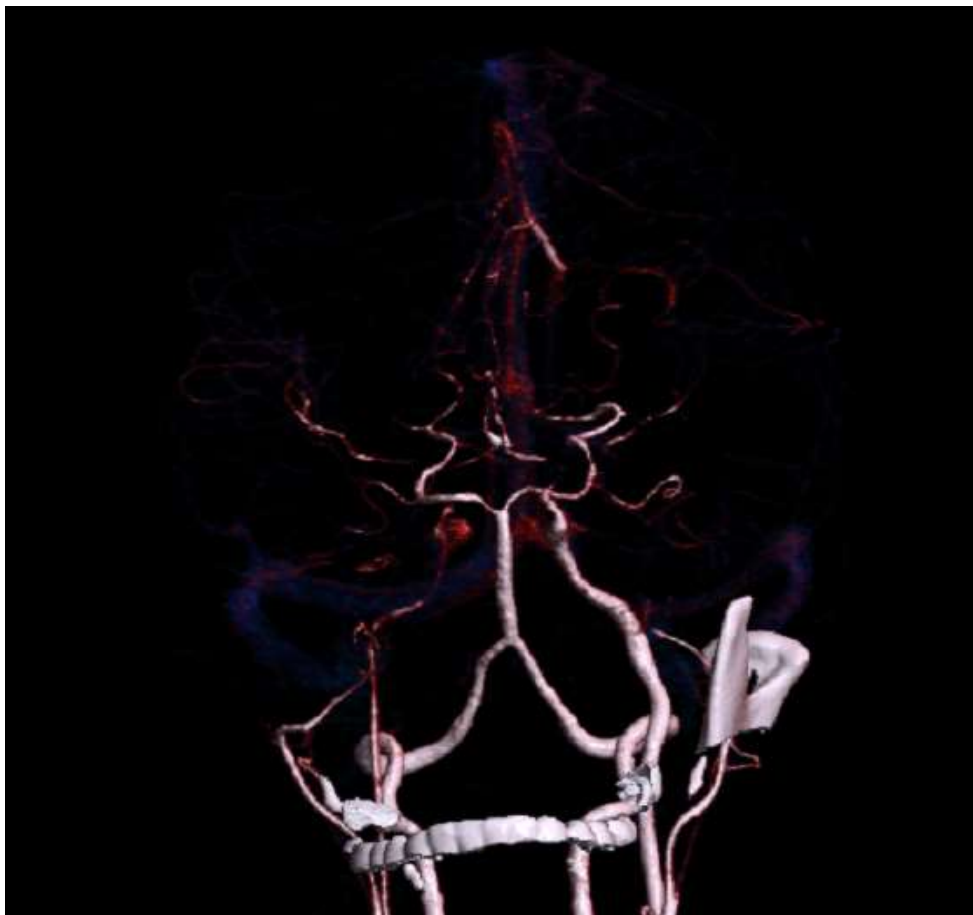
CT angiography revealed significant stenosis of supraclinoid segment of right ICA with reformatting of ACA and MCA via collaterals. Similar stenosis in left ICA, proximal A1 segment of left ACA and M1 segment of left MCA. Distal MCA and ACA are reformatted via collaterals. Multiple collaterals are noted in bilateral sylvian fissures along course of MCA.
